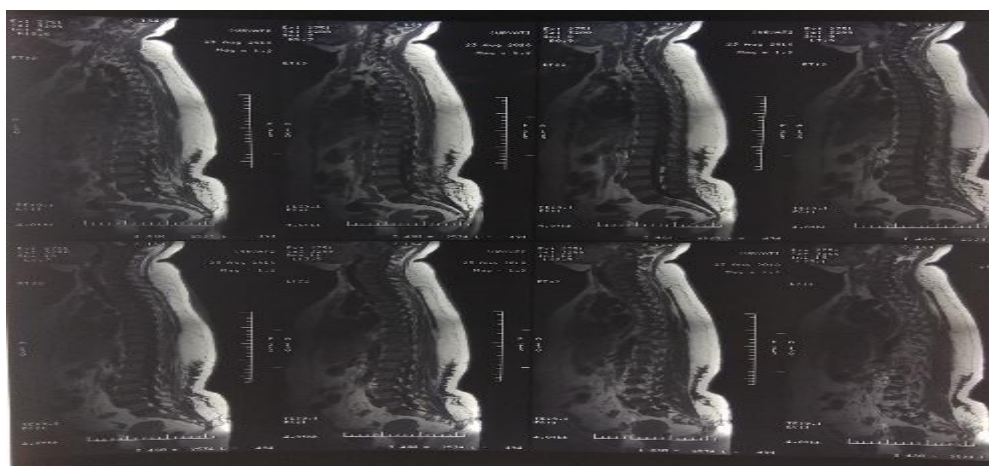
After administration of intravenous immunoglobulin. Whole spine T1 weighted MRI with and without contrast showing no abnormal hypo/hyperintense lesion in spinal cord, which on contrast enhancement did not appear. Multilevel bulging disc causing mild to moderate compression of the anterior dural sac, severe at levels VL 4-5, VL5-VS1, thickening of the ligamentum flavum, hypertrophy and facet joint effusion, causing mild to moderate narrowing of the right and left lateral recess (severe at level VL 4-5, VL5-VS1) and mild foraminal neural stenosis at VL 4-5, VL5-VS1 levels.
